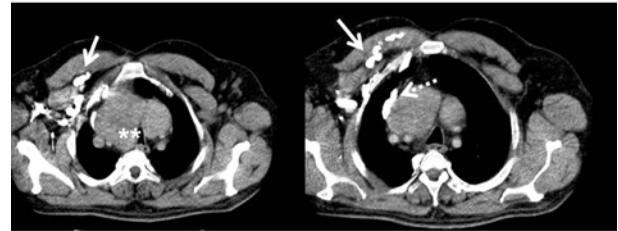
Thorax computed tomography indicating retrosternal goiter (), compressing vena cava superior (dotted arrow), and the dilated superficial veins (white arrows)
